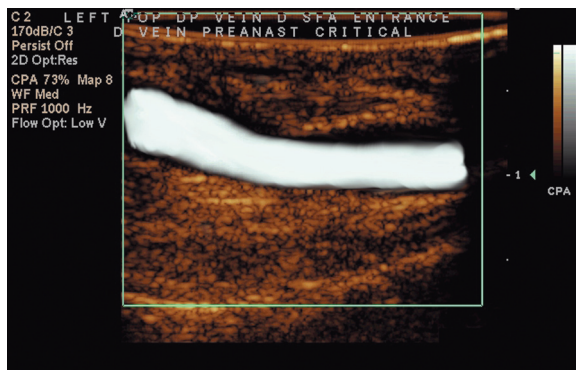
Power Doppler image of the same location taken after balloon deflation and removal demonstrated complete stenosis resolution and absence of luminal defects in the bypass
